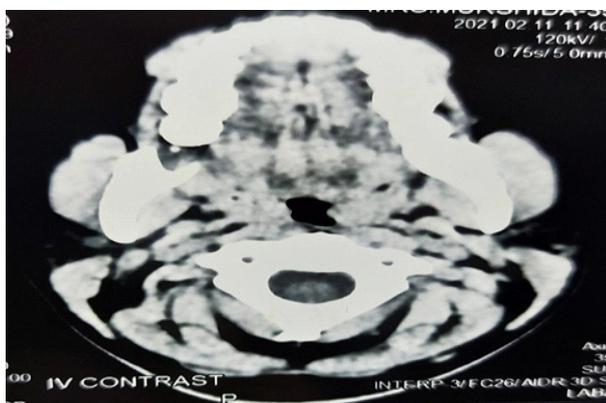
Computed tomography (CT) Scan showing soft tissue expansile mass on right retromolar trigone. Minor Salivary gland tumor, mucocele and Myxoma was thought to be as differential diagnosis.
